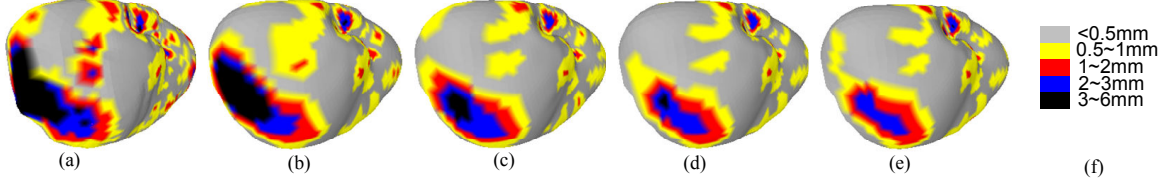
Reconstruction error with iterations:(a) Ultrasound registration, (b) Reconstruction using constant weights, (c) Reconstruction with “local” weights without iteration, (d) Reconstruction with “local” weights with 5 iterations, (e) Reconstruction with “local” weights with 7 iterations, (f) Color legend for the error.
